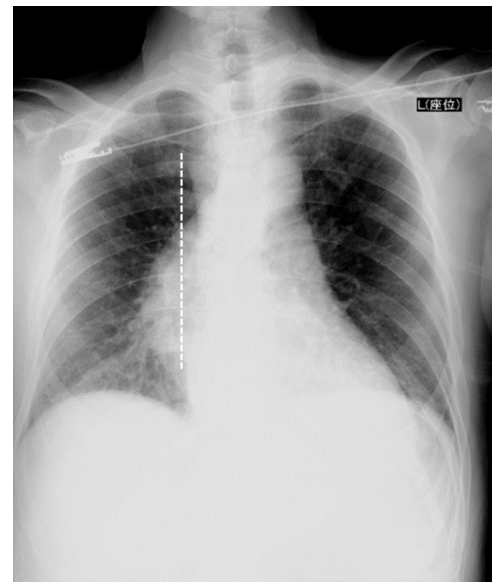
Chest radiograph (AP view) showing the right-sided aortic arch (white dotted line).
